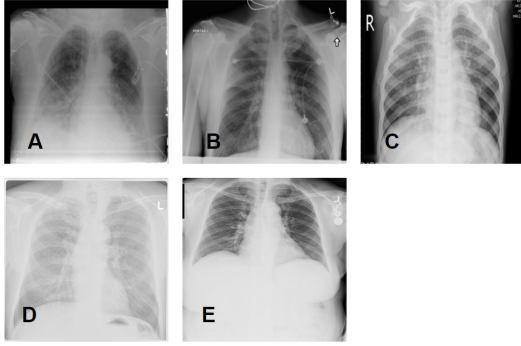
Sample X-ray images from the dataset. COVID-19 positive X-Ray image(A), Lung Opacity X-Ray image(B), Viral Pneumonia X-Ray image(C), Tuberculosis X-Ray image(D), and Normal X-Ray image(E)
